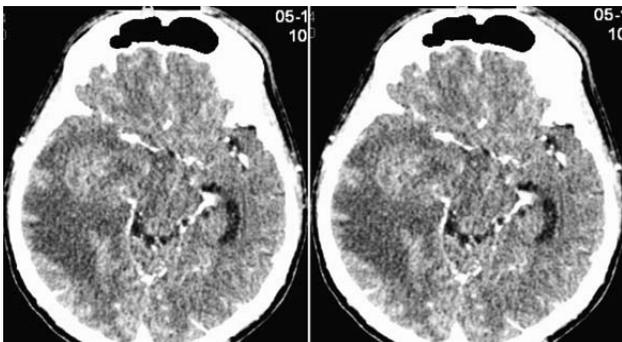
Figure I & II- CT scan showed multiple well defined peripherally enhancing lesions seen in the right temporo-parieto-occipital region.
